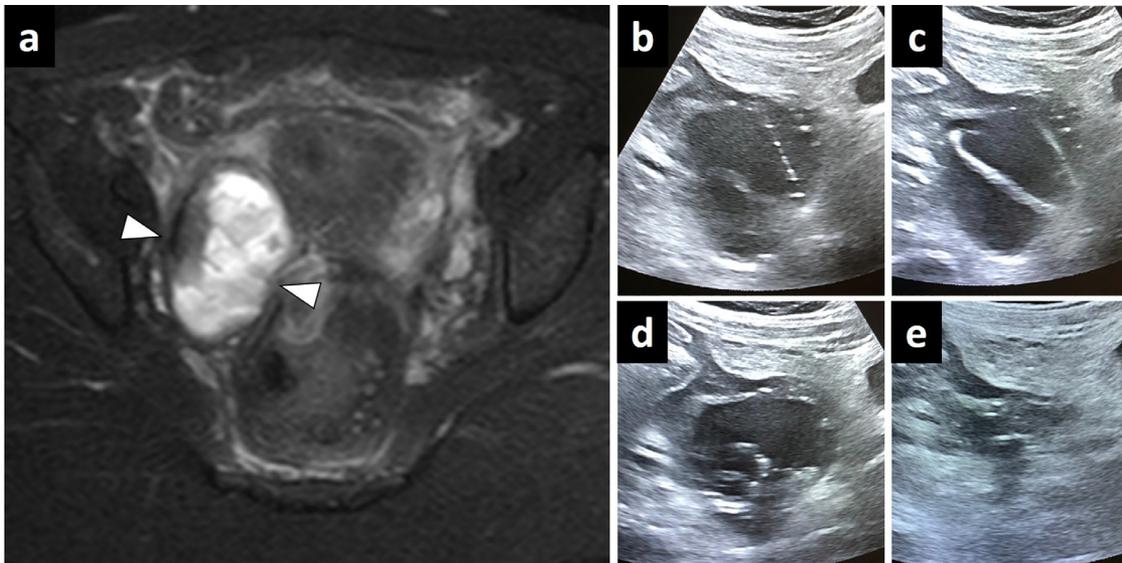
Extensive pelvic inflammation and percutaneous drainage. (A) Axial plane fat-suppressed T2W image of follow-up MRI on day 11 demonstrates almost complete «disappearance of T2 shading» in the right adnexal lesion (arrowheads, A) and extensive T2 hyperintensities throughout the pelvic fat planes, consistent with inflammation. (B–E) Axial plane gray scale US images of the percutaneous drainage procedure. The lesion was punctured with an 18G hollow needle under US guidance (B). After obtaining the aspiration sample for microbiological examination, a guide wire was introduced through the needle (C). The 8F drainage catheter was advanced into the cavity over the guide wire (D). After catheter insertion, approximately 70 mL of hemopurulent content was evacuated, and almost complete resolution of the lesion was observed (E). The catheter was left in place to allow free drainage, and the initial aspiration sample was sent for microbiological examination.
